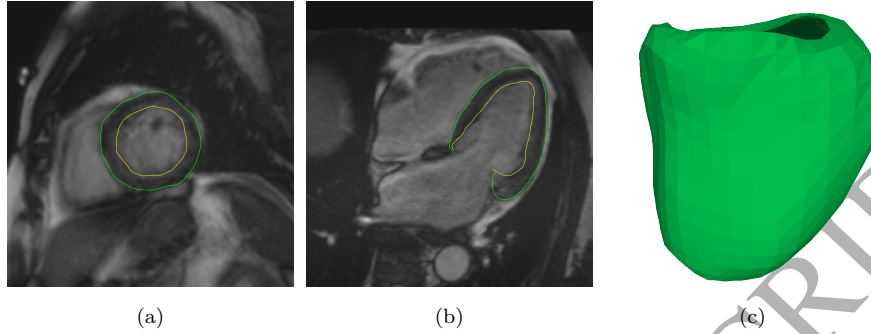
MR image segmentation. (a) Segmented short axis slice. (b) Segmented long axis slice. (c) Reconstructed 3D epicardial shell.
